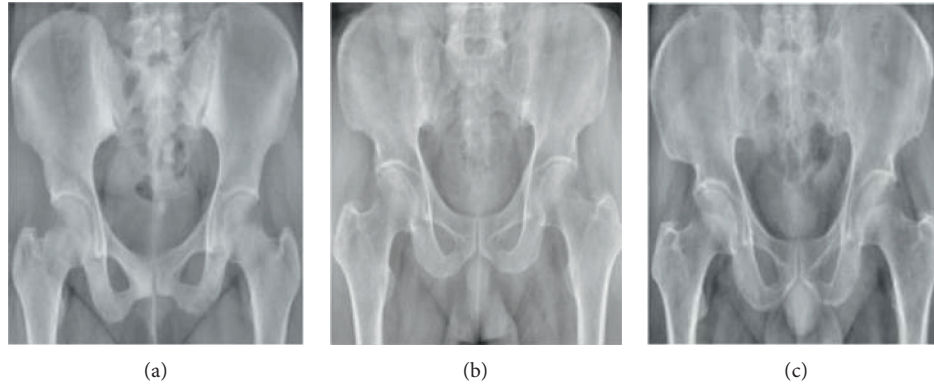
Some examples of pelvis acquired by X-Ray imaging: (a) normal bone mass, (b) lower bone mass, and (c) osteoporosis [75].
